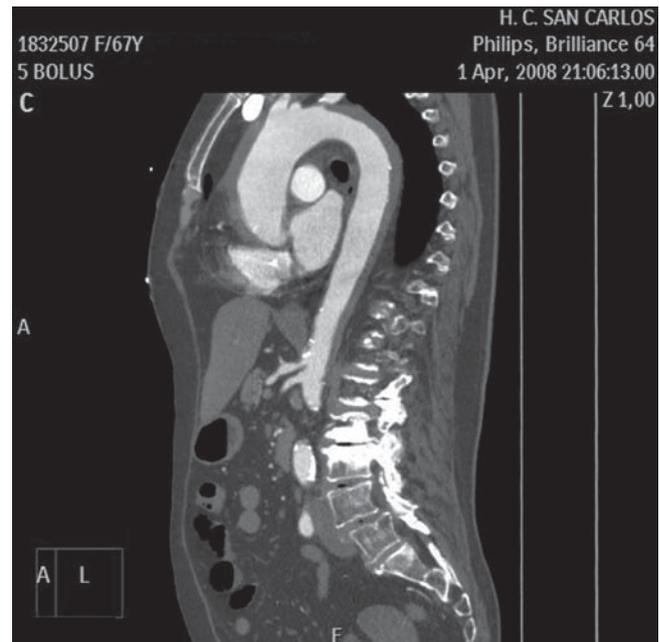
Sixty-four-row multi-detector CT of a type A intra-mural aortic haematoma. Sagittal modified view using multi-planar reformatted maximum pixel intensity depicting the non-spiral thickening of the aortic wall extending through the ascending aorta, the arch, and the descending thoracic aorta up to the exit of the celiac trunk and superior mesenteric artery. The haematoma includes the rise of the innominate artery
